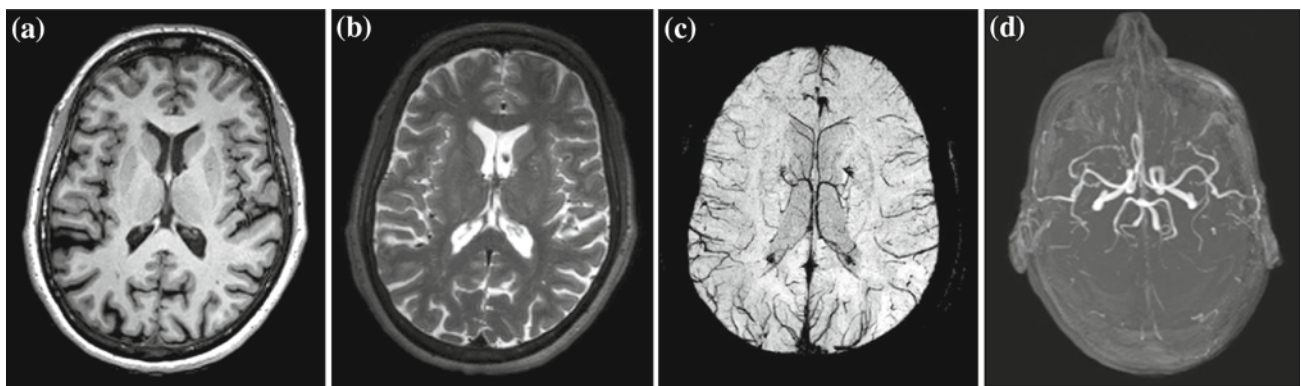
Multi-modal MRI acquisition protocol. a T1w, b T2w, c SWI, d TOF
